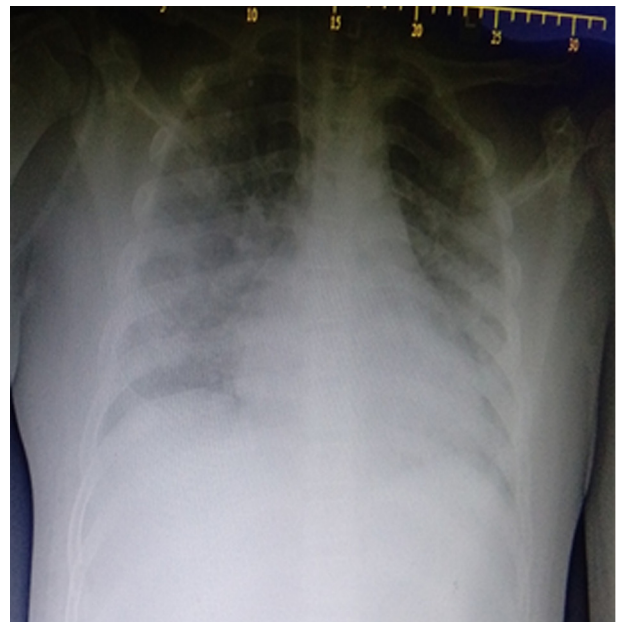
Chest radiograph on admission showing bilateral uniform opacities with a peripheral distribution
